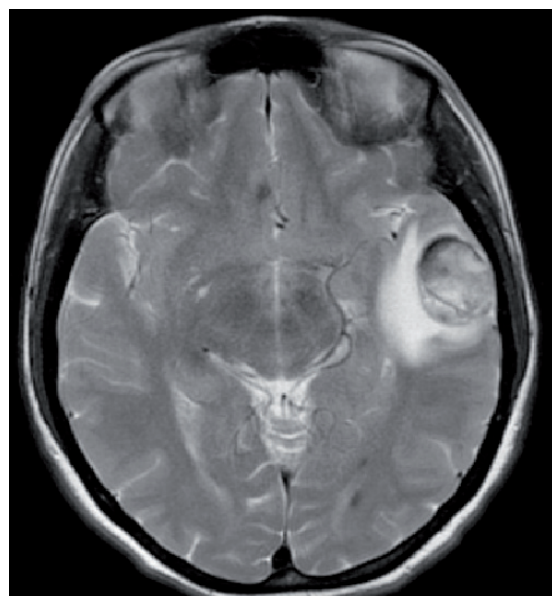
Type I cavernoma revealed in T2-weighted SE sequence.
